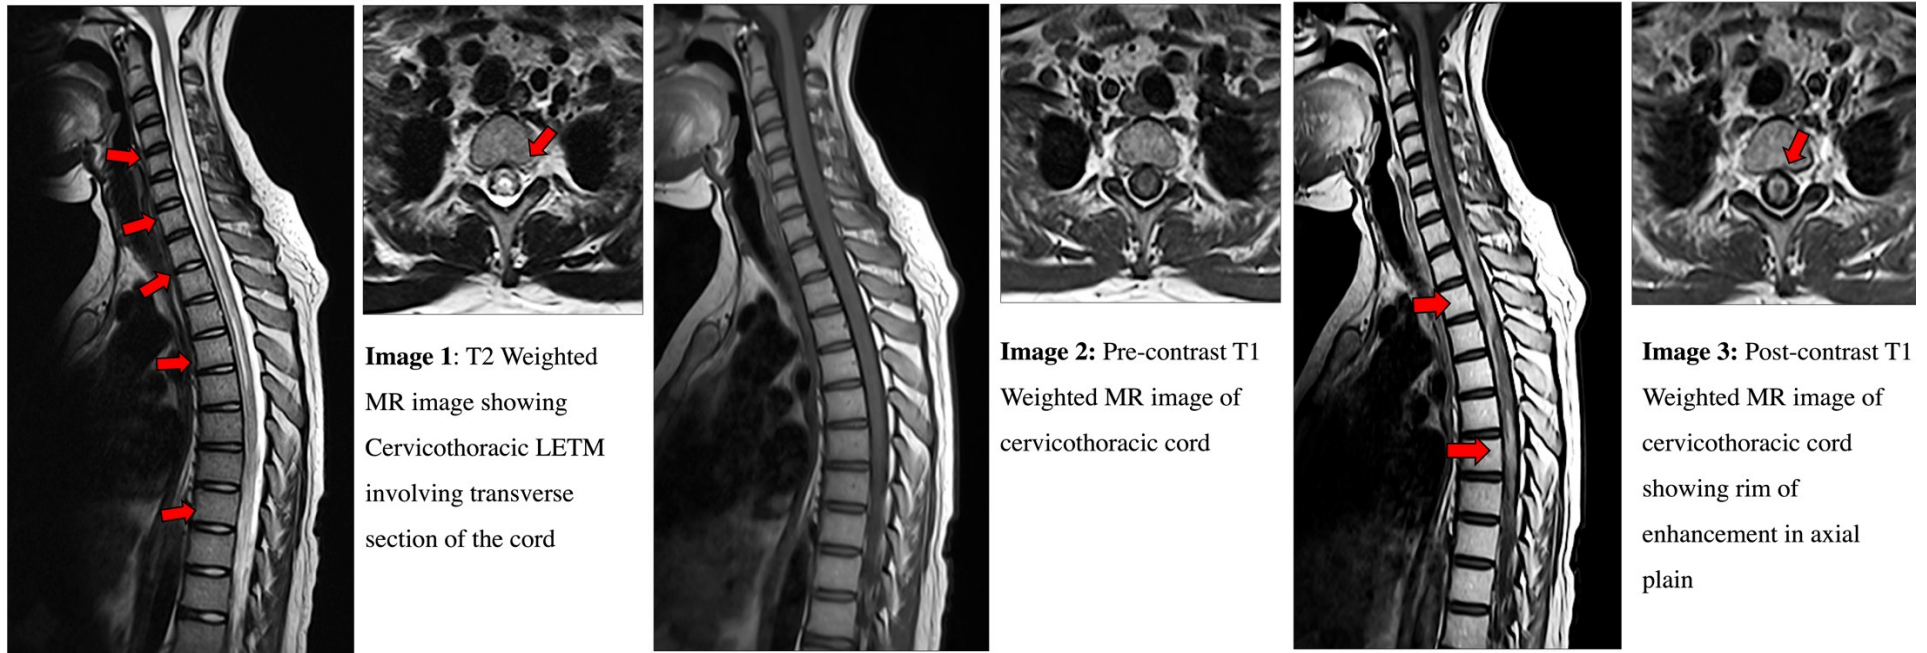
An example of the cervicothoracic MRI spine imaging characteristics of AQP4-Ab-positive NMOSD case. In Image 1 note the T2-weighted image showing LETM in the axial plane and central cord hyperintensity in the axial plane. The Images 2 & 3 show the corresponding sagittal and axial T1-weighted Pre and Post Gadolinium contrast enhanced MRI sequences. In Image 3 there is “cigar-like” pattern of enhancement in post-contrast sagittal image and rim of enhancement in the axial plane.
